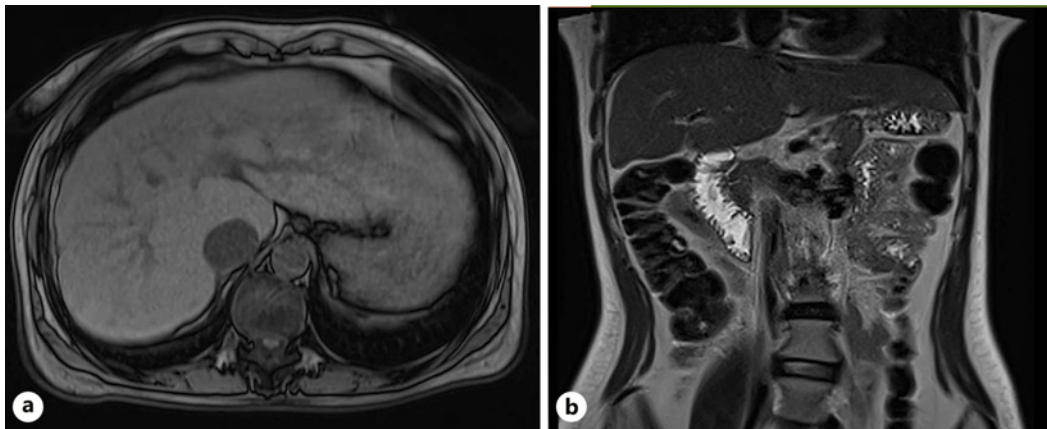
Magnetic resonance imaging of the liver; (a) axial and (b) coronal view showing atrophic right lobe, enlarged left lateral segment.
